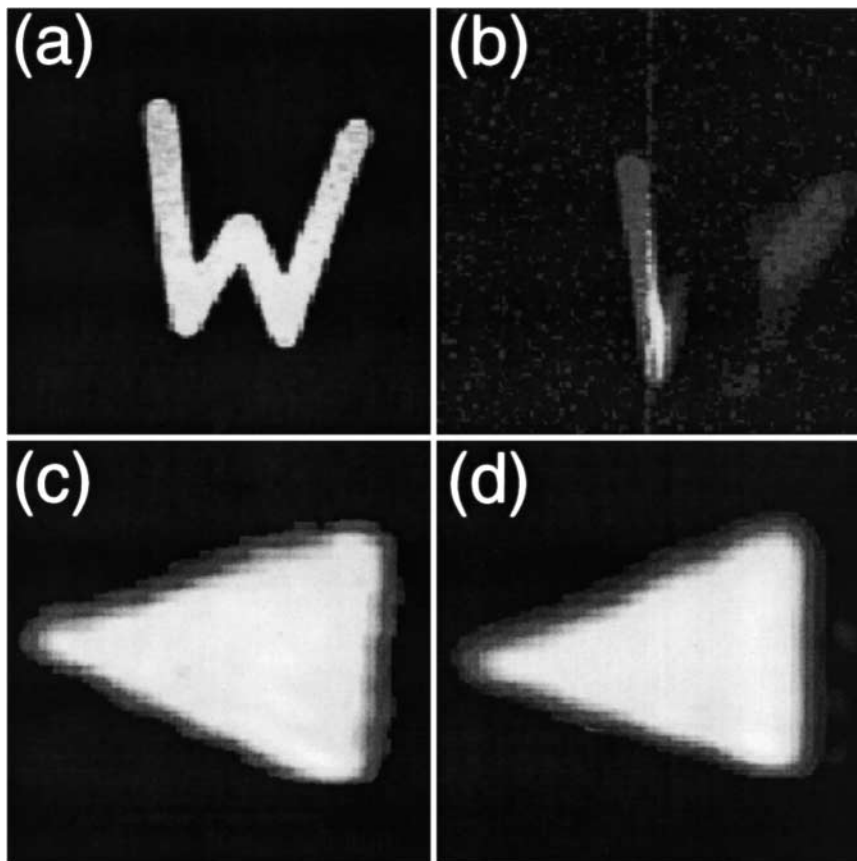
Demonstration of low-field MRI of polarized gases with greatly reduced magnetic susceptibility distortions (277). (a) Room-temperature high-field ^1H MR image from a water-filled W-shaped cell. (b) Same as (a), but with paramagnetic materials placed near the cell. (c) Low-field (21 G) ^3He MR image from a triangular glass cell containing laser-polarized helium gas. (d) Same as (c), but with the cell placed near the paramagnetic materials. Images were obtained with a standard gradient echo imaging sequence, and the signal was detected with a conventional Faraday induction coil. Figures courtesy of Glenn Wong and Ronald Walsworth.
